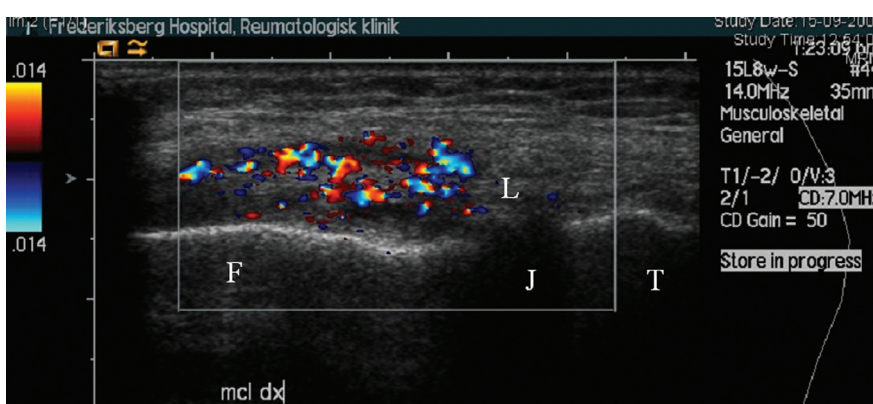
Partial rupture of the right MCL. Longitudinal images of the proximal origin of the MCL ligament. The ligament is swollen with hypoechoic spot indicating fluid and partial rupture. There is Doppler activity in the ligament indicating hyperaemia and acute injury. L: MCL-ligament; J: joint line (with meniscus); F: femur; T: tibia bone.
